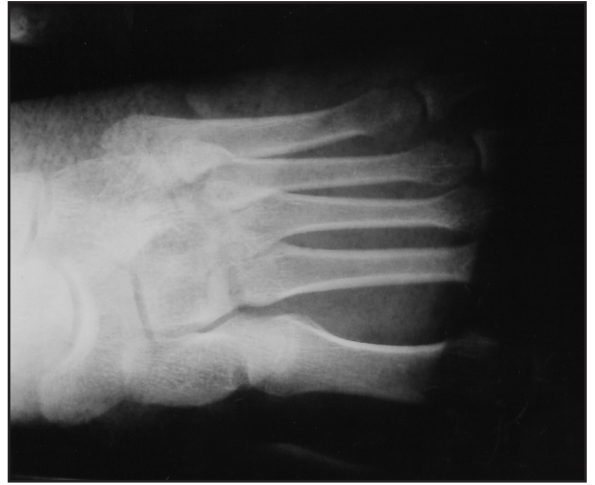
Ligamentous tarsometatarsal joint injury presented as a symptomatic foot with no obvious x-ray findings in non weight bearing films
